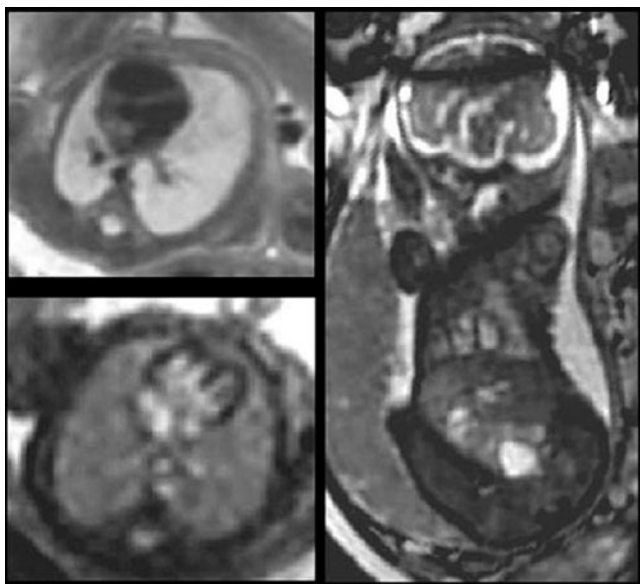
Fetal cardiac MRI by black blood (top left) and fast SSFP through the axial plane (bottom left) of the heart, and the entire fetus (right). Note delineation of the ventricular chamber size in the 4-chamber view
